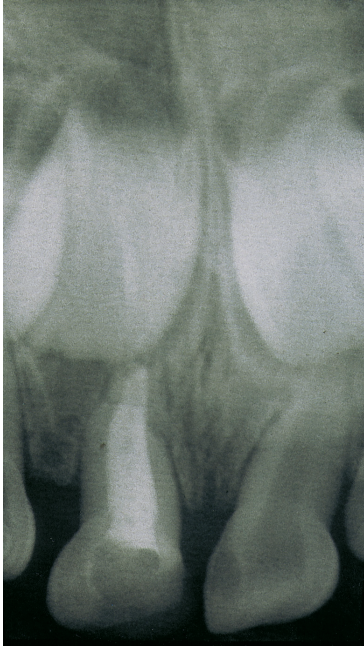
Periapical radiograph shows completion of pulpectomy. Note the talon cusp has been removed.
